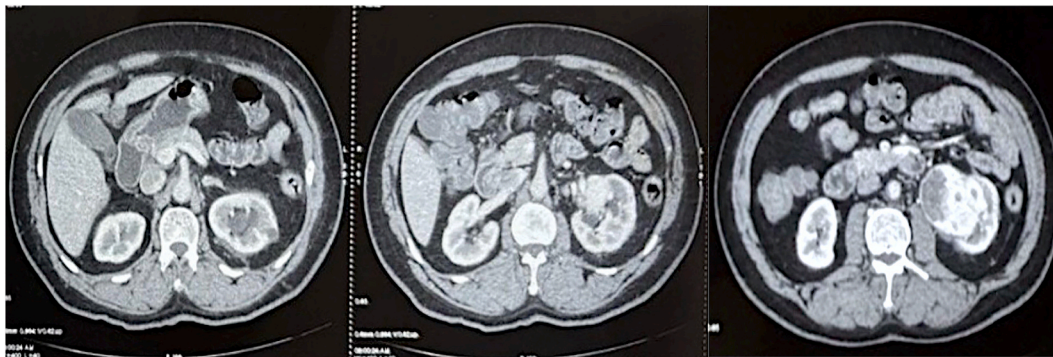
Contrast-enhanced CT urography showing a 6 × 5 × 4 cm heterogeneously enhancing lesion arising from and involving the renal pelvis, associated with mild hydronephrosis.
